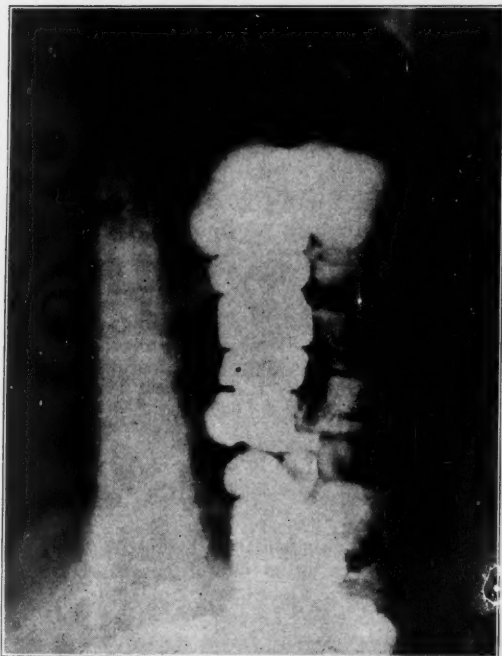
Roentgenogram showing a portion of the colon herniated high into the left pulmonic field.
